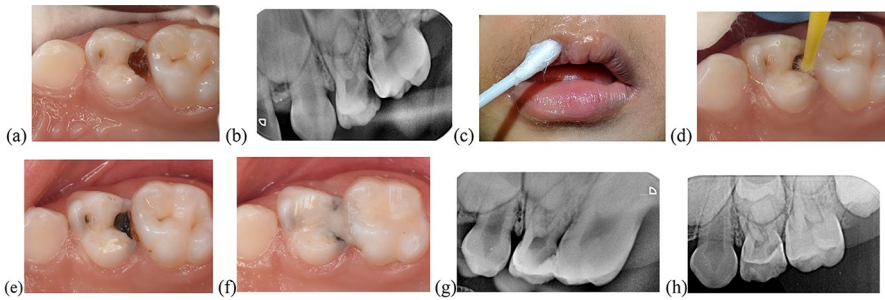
SDF application in posterior carious lesions with no signs or symptoms of pulp pathology. a Preoperative deep dentinal carious lesion on the disto-occlusal surface of tooth 64. b Preoperative radiograph showing carious lesion involving inner third of dentin on tooth 64. c Perioral application of petroleum jelly. d Scrubbing of SDF into the lesion with a micro-brush after air-drying the lesion. e Well-arrested shiny dark lesion. f Tooth 64 was restored with high-viscosity glass ionomer cement—silver diamine fluoride modified atraumatic restorative technique (SMART). g Post-operative radiograph of tooth 64. h Note the lesion arrest and increase in remineralized zone between the lesion and pulp at 18-month follow-up
